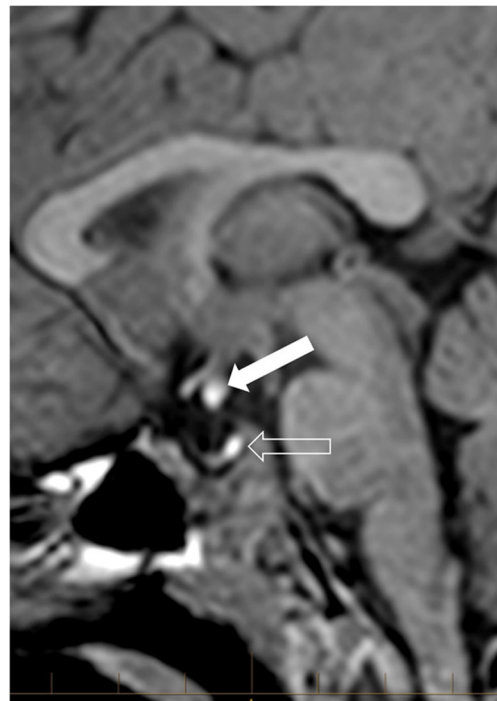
Case 1, a boy age 4 years 6 months. T1-weighted fat-saturated sagittal midline MR head image shows a second and ectopic T1 bright spot in the midline at the infundibulum (*solid arrow*). A T1 bright spot also appears in the sella (*open arrow*)
